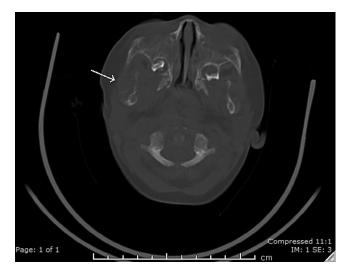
Axial computed tomography image with bone reconstruction shows aggressive periosteal reaction centered at the ramus of the right mandible.
